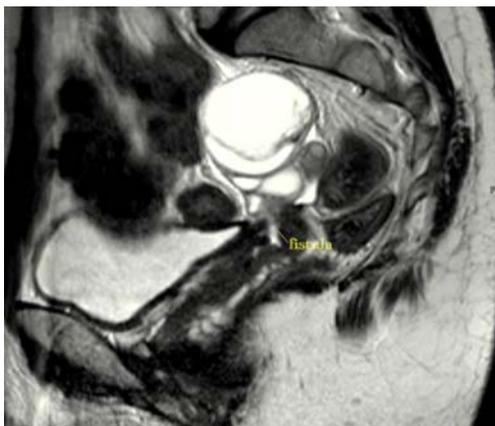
Preoperative magnetic resonance imaging (MRI) showing the fistula between the vagina and the left adnexa, probably the left fallopian tube
